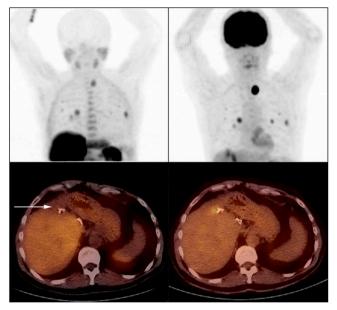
Maximum-intensity-projection images showing 2 liver foci, both hot on <sup>18</sup>F-fluorocholine PET (left) but not visible on <sup>18</sup>F-FDG PET (right) images. Both liver foci corresponded to untreated well-differentiated HCC.
